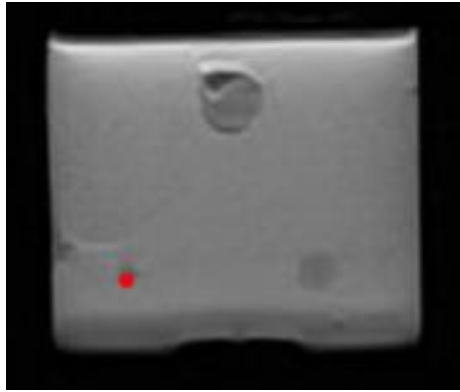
Target location as set on MRI image in the biopsy software (small tumour).
